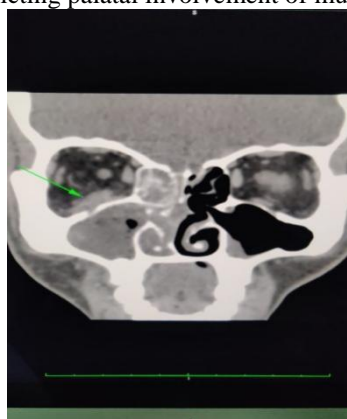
Radiographic scan to evaluate the sinus and palate condition
